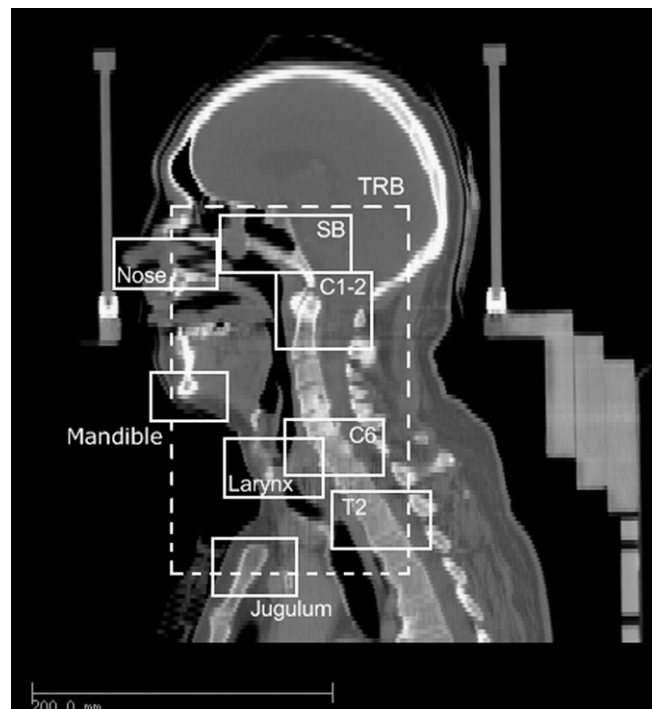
Definition of registration boxes in sagittal view on planning computed tomography scan, including stereotactic frame.
